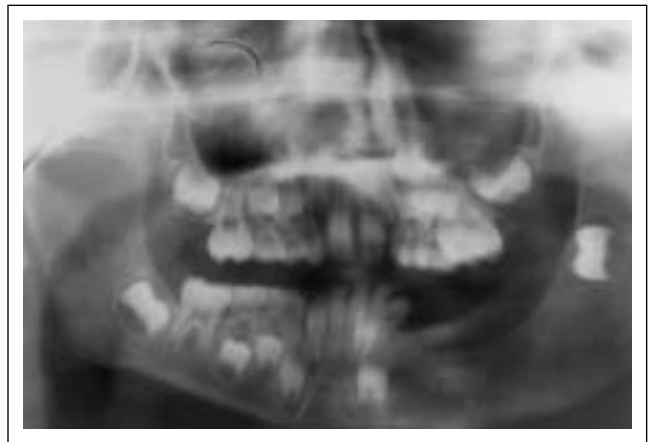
Panoramic radiographic taken at 6 months after surgery.
